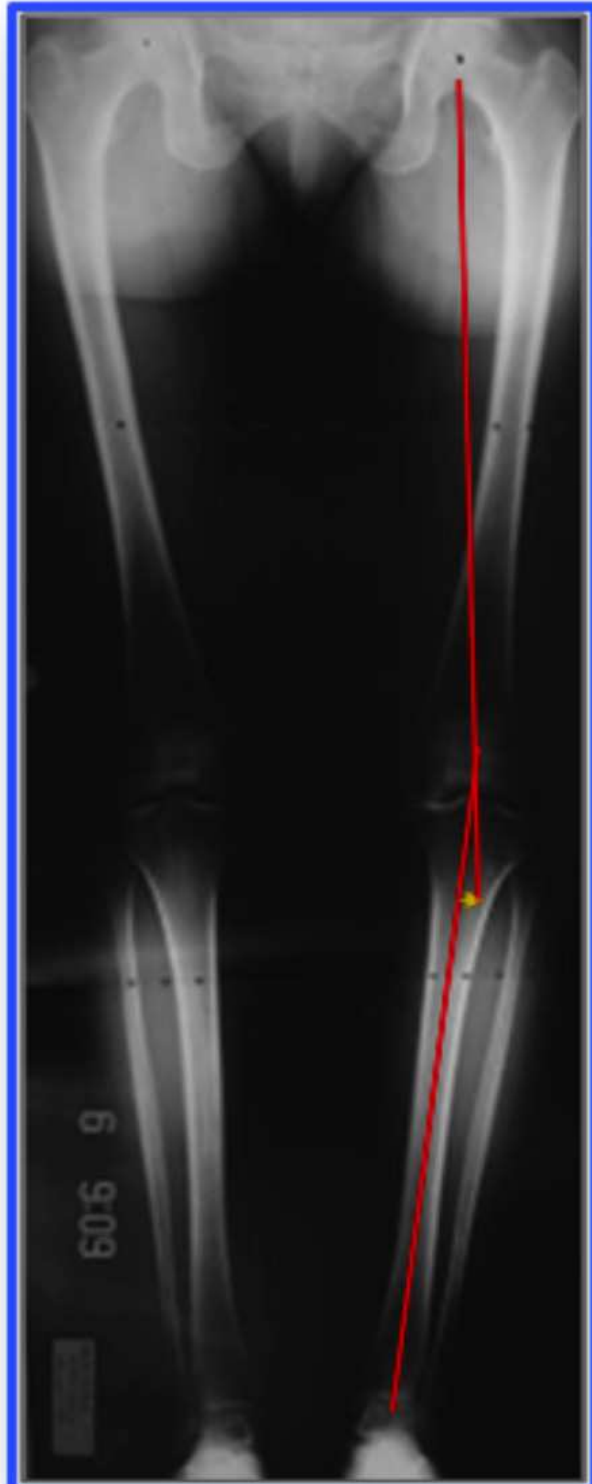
Panoramic radiography with full weight-bearing on the lower limbs with measuring of the mechanical axis
